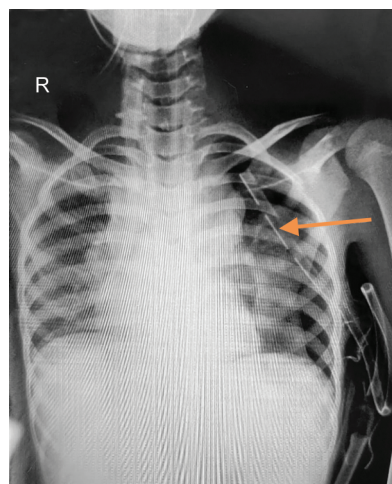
Chest X-ray with ICT tube *in situ* and resolving pneumothorax
